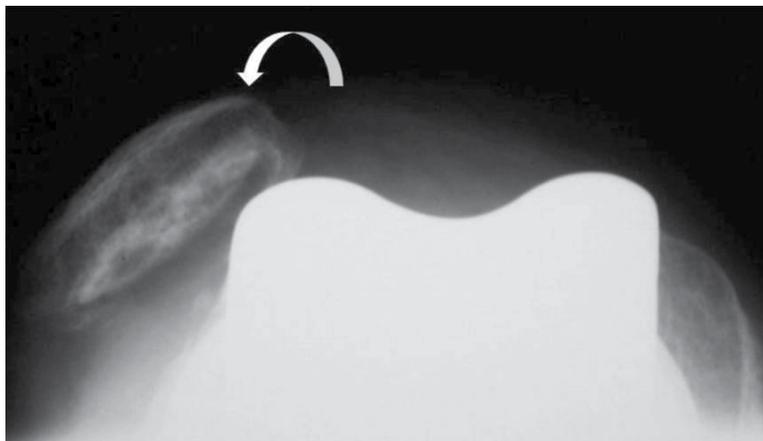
Patellar Dislocation. A 71-year-old woman, five years after total knee replacement. Axial radiograph (Merchant view) of the knee prosthesis with cemented prosthetic button of the patella demonstrates lateral patellar displacement on flexion (curved arrow).
